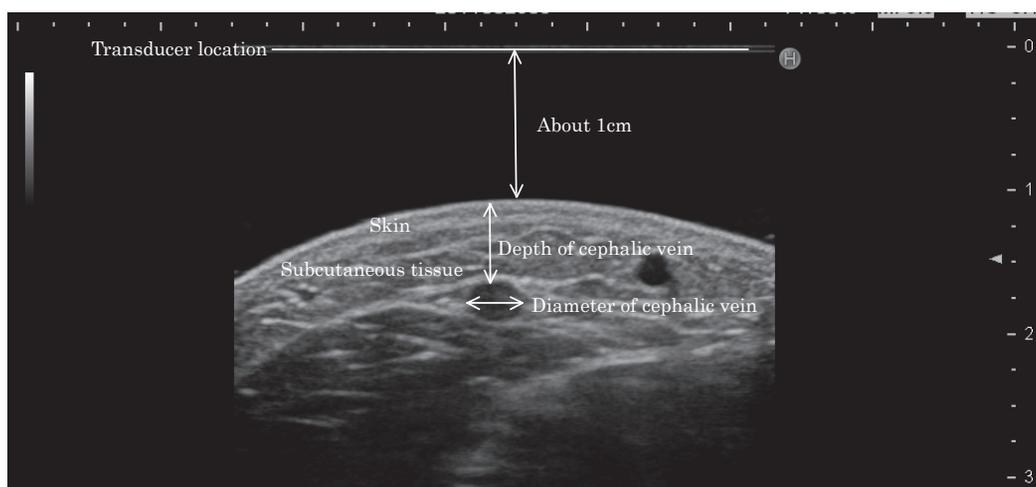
Ultrasound image of a vein in the short-axis view taken using the ultrasonic diagnostic device with a 15-MHz linear transducer. The vein is the black circle in the center of the image. As the subject's arm is immersed in water, the skin's surface and the position of the ultrasound probe transmission are separated by approximately 1 cm.
